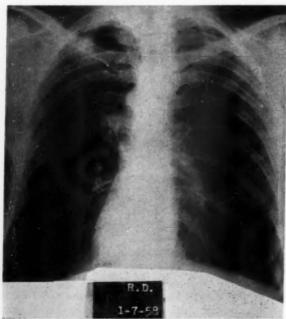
Same case. Chest roentgenogram taken January 7, 1958, showing healed left apical lesion with residual linear scarring.
